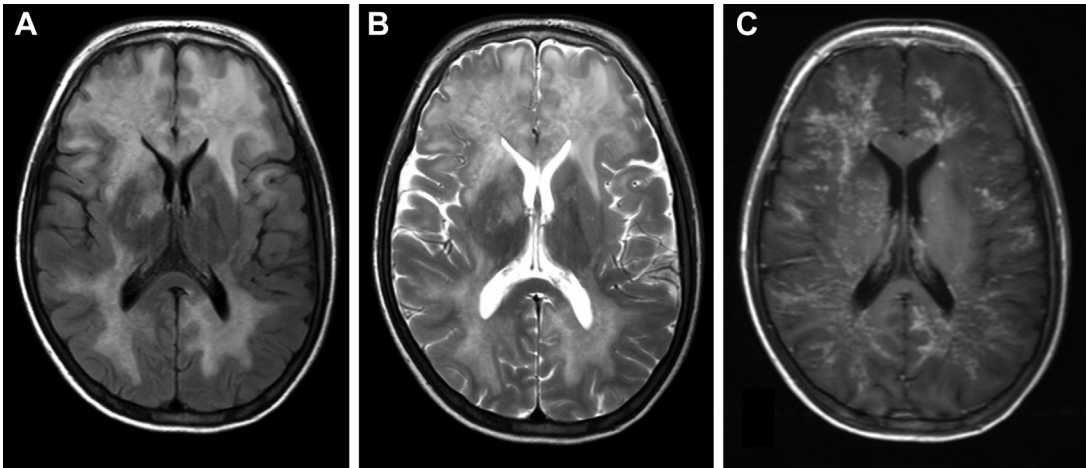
Tuberculous encephalopathy. Axial FLAIR (A) and T2-weighted images (B) show severe symmetric diffuse white matter edema. Axial T1-weighted postcontrast MR imaging shows diffuse white matter contrast enhancement (C).
